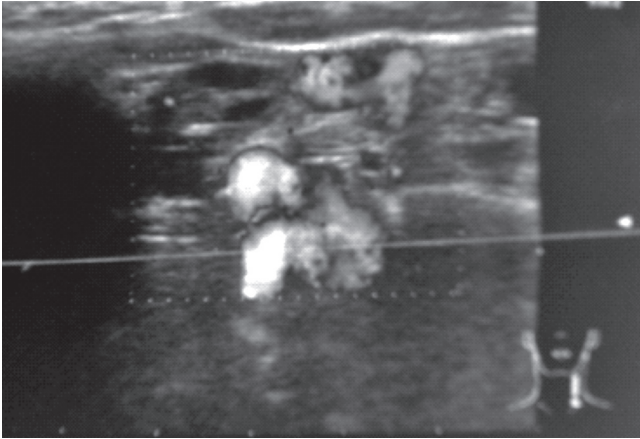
Doppler ultrasound scan of the neck showing the enlarged parathyroid gland with increased vascularity
